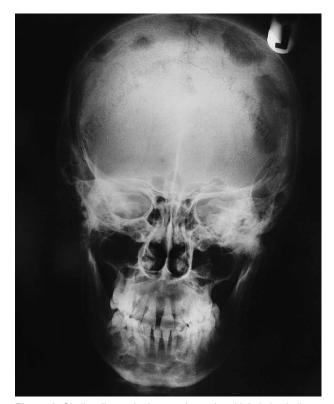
Skull radiography image showed multiple lytic skull lesions.
